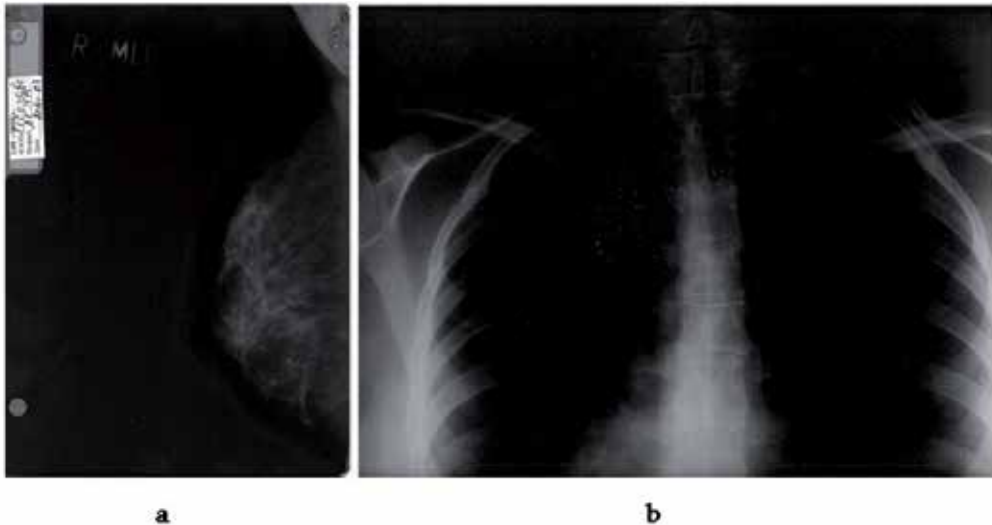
Patient E. X-ray examination of the breasts (a,b) and the chest in two years after the breast lifting with installation of a reticular implant.
